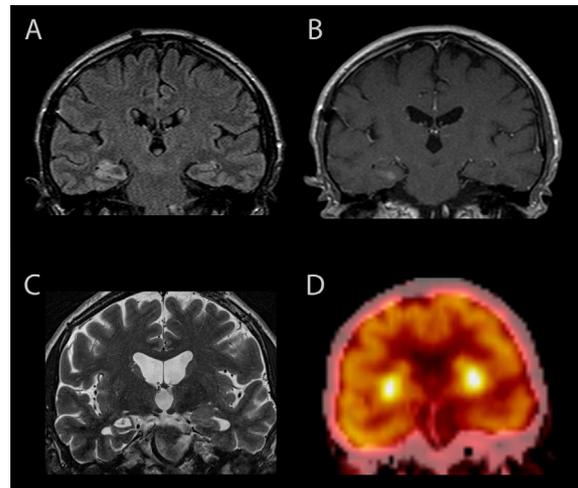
MRI and FDG–PET imaging in LG11 encephalitis. (A–C) 60-year-old male patient with LG11 encephalitis: FLAIR-hyperintense signal alterations in the hippocampus bilaterally (right > left; A), with contrast enhancement on the right side (B). The patient presented with frequent faciobrachial dystonic seizures (FBDS), followed by confusion, agitation, and severe memory impairment. Following immunotherapy with IV steroids, plasma exchange and IV immunoglobulins FBDS ceased while memory impairment persisted. Follow-up MRI 17 months later showed bilateral (right > left) atrophy of the hippocampus as well as moderate global atrophy (C). (D) FDG–PET showing bilateral hypermetabolism in the basal ganglia in a 92-year-old patient that presented with up to 100 FBDS/day but without cognitive deficits. FBDS stopped after two courses of IV immunoglobulin therapy. MRI was unremarkable except mild global atrophy and microangiopathic leukoencephalopathy and especially showed no abnormalities of basal ganglia or medial temporal lobes ([Fidzinski et al., 2014](#)).
